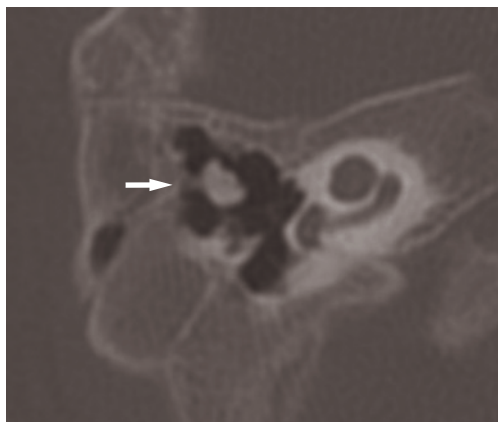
Axial CT scan. Abnormal fusion of the head of the malleus with the body of the incus; fixation of the head of the malleus to the tympanic wall (arrow).
